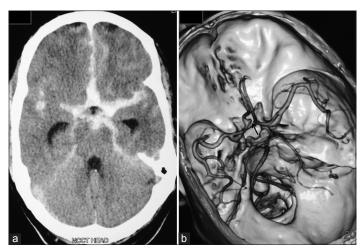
(a) Computed tomogram (CT) head showing subarachnoid hemorrhage in anterior interhemispheric fissure and basal cisterns, (b) CT angiography showing the aneurysm
